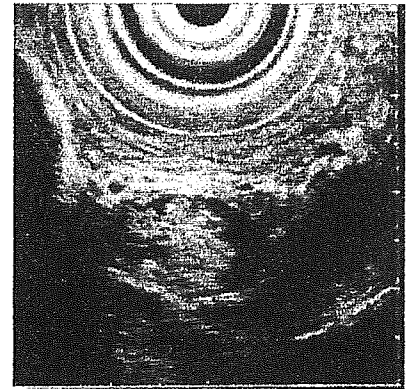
Endosonogram demonstrating a mural nodule in a branch duct IPMN in the head of the pancreas.
